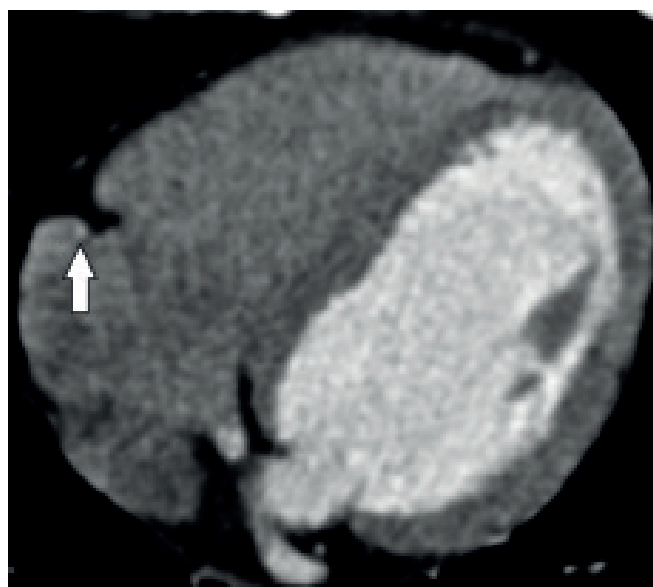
Axial CT angiogram image showing the intracavitary course of the RCA (white arrow) in the right atrial cavity.
